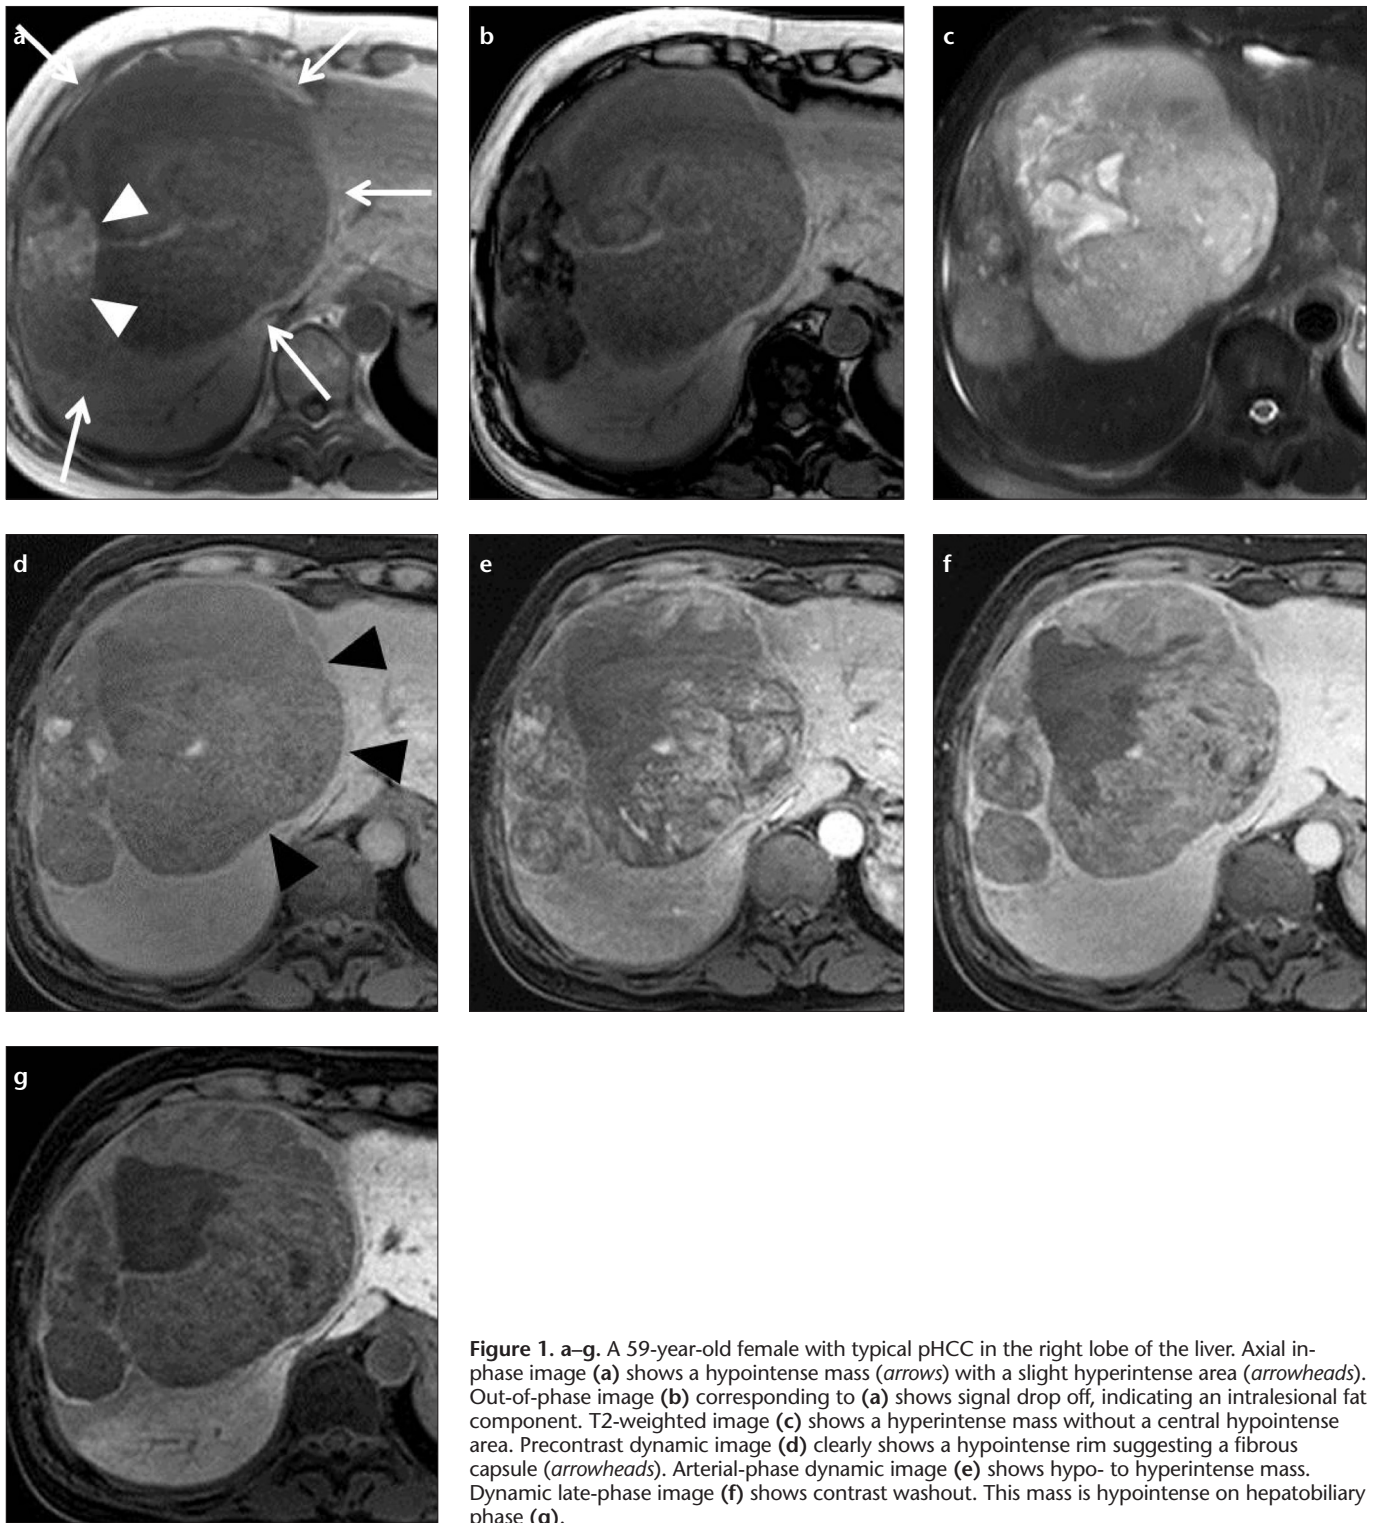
a–g. A 59-year-old female with typical pHCC in the right lobe of the liver. Axial in-phase image (a) shows a hypointense mass (arrows) with a slight hyperintense area (arrowheads). Out-of-phase image (b) corresponding to (a) shows signal drop off, indicating an intralesional fat component. T2-weighted image (c) shows a hyperintense mass without a central hypointense area. Precontrast dynamic image (d) clearly shows a hypointense rim suggesting a fibrous capsule (arrowheads). Arterial-phase dynamic image (e) shows hypo- to hyperintense mass. Dynamic late-phase image (f) shows contrast washout. This mass is hypointense on hepatobiliary phase (g).
